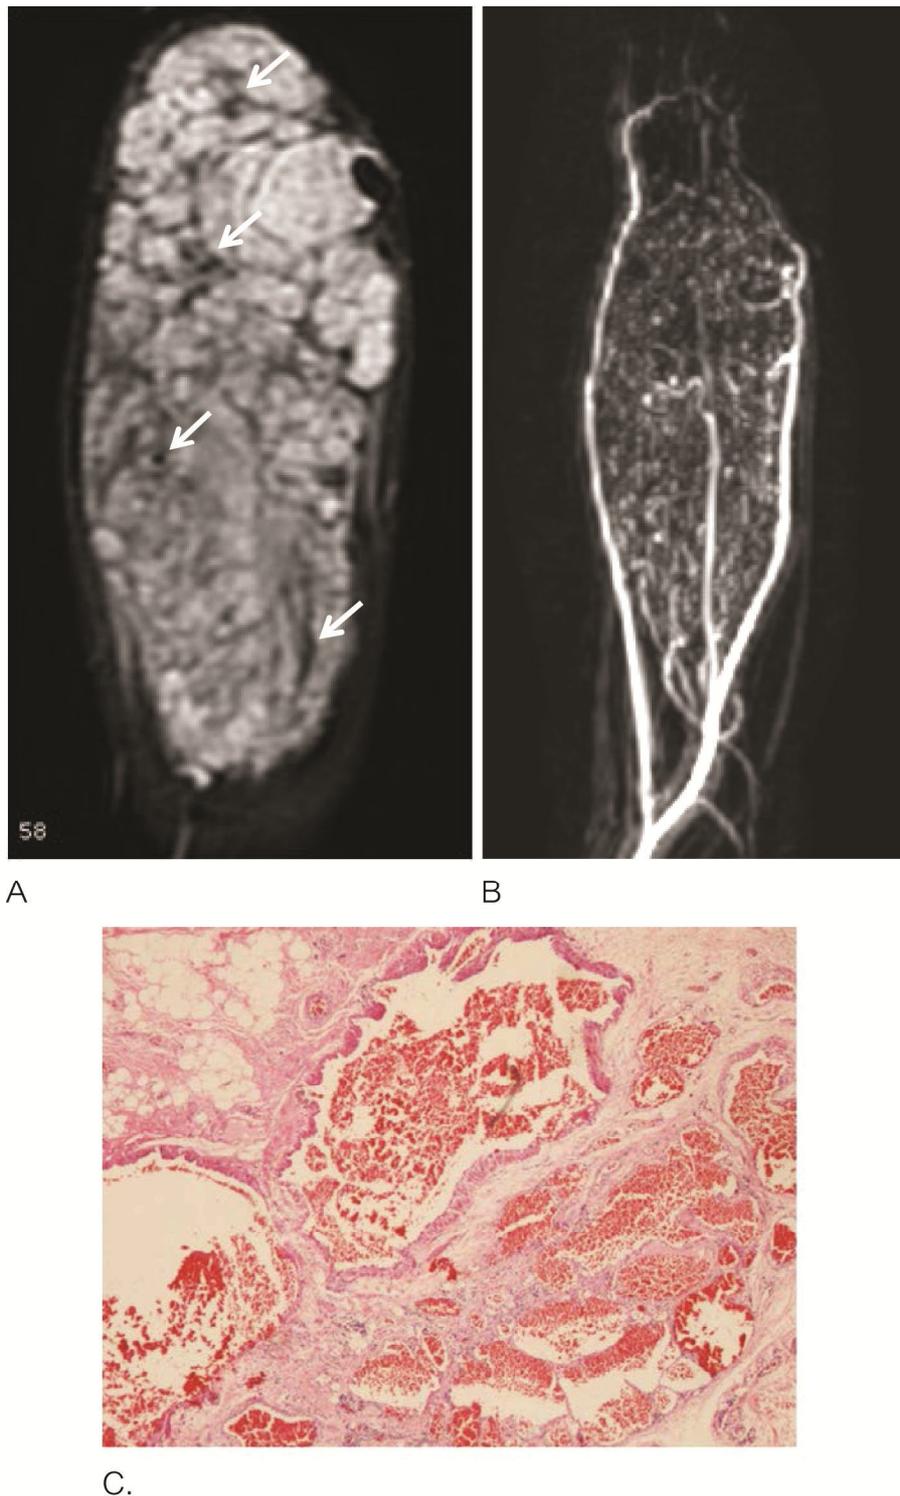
MR imaging of the right forearm of a 22-year-old woman. A.) Coronal T2-weighted image with fat suppression shows the large mass with multiple flow void artifacts (arrows). B.) Coronal subtraction MIP image from multi-phase MRA shows enhancement of the mass in arterial phase. These findings suggest AVM. C.) The pathological diagnosis is venous malformation.
